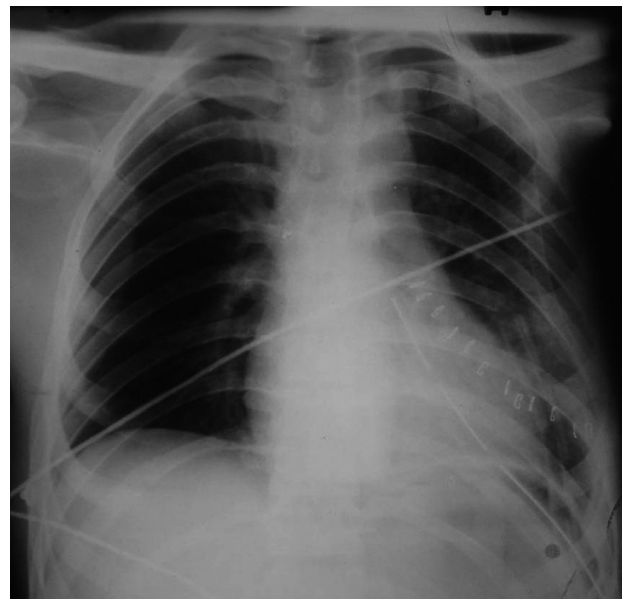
Post-operative chest radiograph showing the expanded lung.
